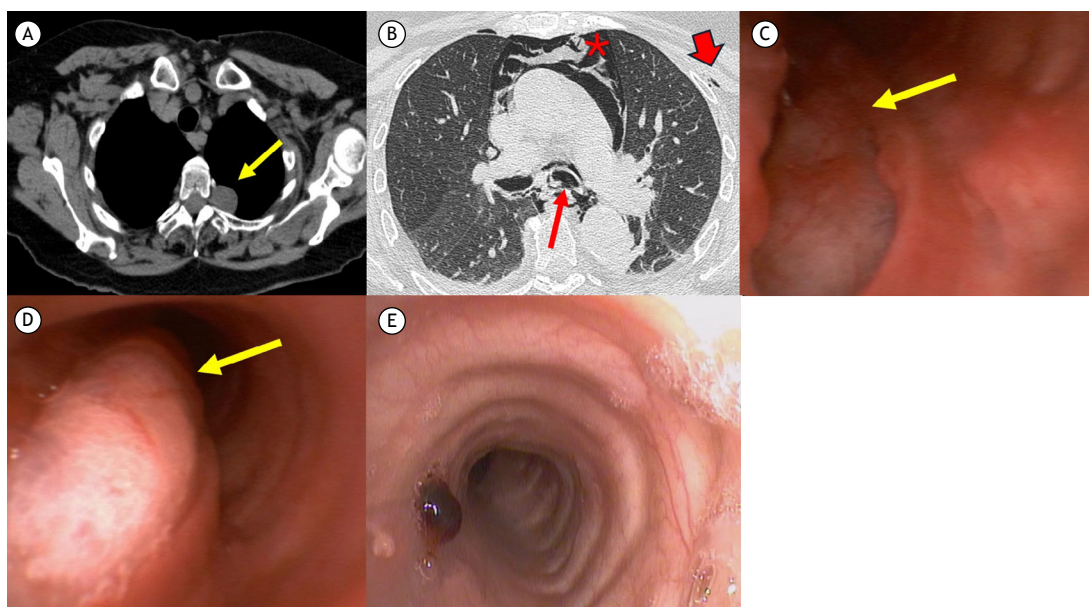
In A, axial unenhanced chest CT scan showing a left apical extrapleural lesion (arrow) arising from the intervertebral foramen, suggestive of a peripheral nerve sheath tumor (schwannoma). The diagnosis was confirmed after resection. In B, postoperative axial chest CT scan with lung window settings, showing a laceration of the posterior wall of the main bronchus (thin arrow). Note pneumomediastinum (asterisk) and mild subcutaneous emphysema (thick arrow). In C and D, bronchoscopic images showing the laceration during inhalation (arrow in C) and the lung protruding into the bronchial lumen during exhalation (arrow in D). In E, a bronchoscopy performed after four months of conservative treatment shows a small amount of granulation tissue on the posterior wall of the left main bronchus, with almost complete closure of the laceration.
